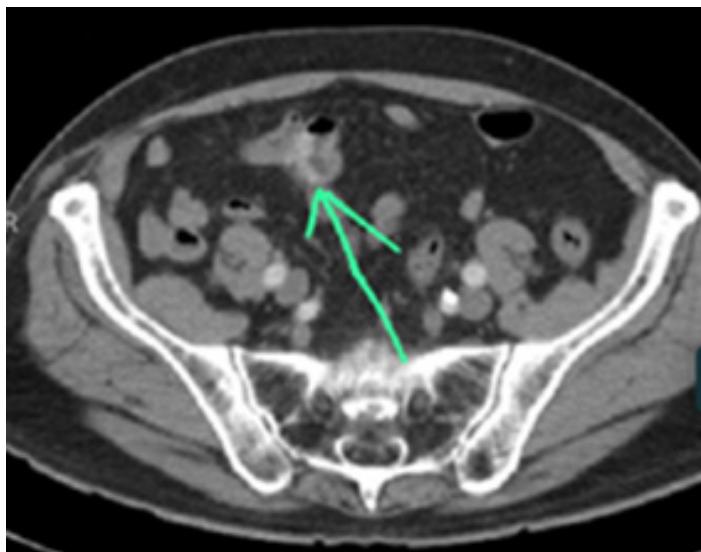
Contrast-enhanced abdominopelvic CT scan. In arterial phase, polypoid formation in the terminal ileal region with heterogeneous enhancement and exophytic growth of submucosal origin. (green arrow) Gastric GIST.
